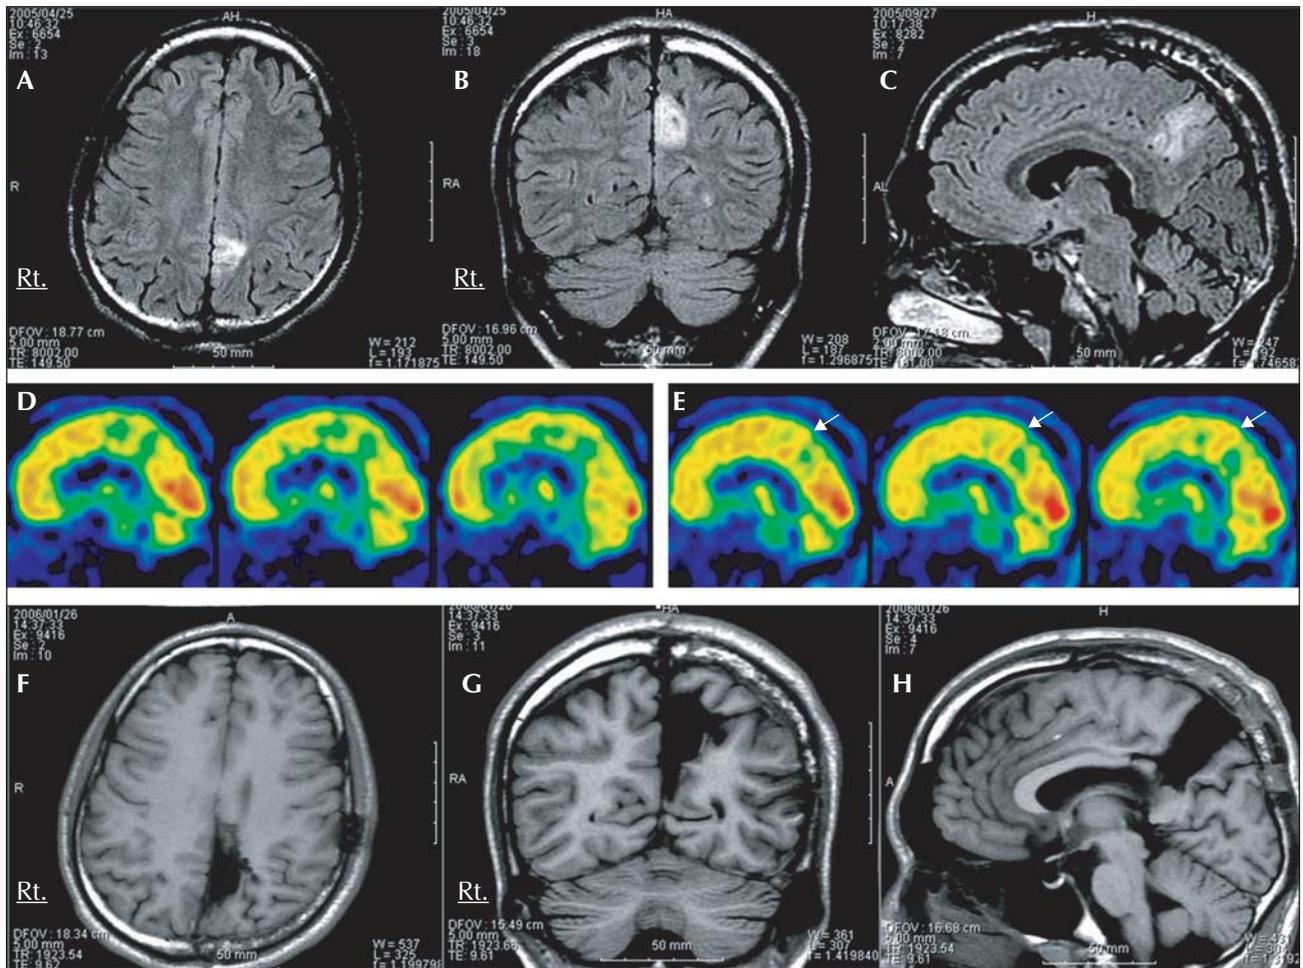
A), B), and C) Preoperative magnetic resonance fluid-attenuated inversion-recovery images revealing a lesion with high intensity signal in the left precuneus; axial, coronal, and sagittal, respectively. D) Consecutive sagittal images of interictal technetium-99m-ethyl cysteinate dimer (^{99m}Tc -ECD) SPECT showing an area of hypoperfusion around the precuneate lesion. E) Consecutive sagittal images of ictal ^{99m}Tc -ECD SPECT demonstrating increase of cerebral blood flow around the precuneate lesion, especially the anterior portion, during seizure (arrows). F), G), and H) Postoperative magnetic resonance T1-weighted images demonstrating the left precuneus gyrectomy including the cortical dysplastic lesion: axial, coronal, and sagittal, respectively.
